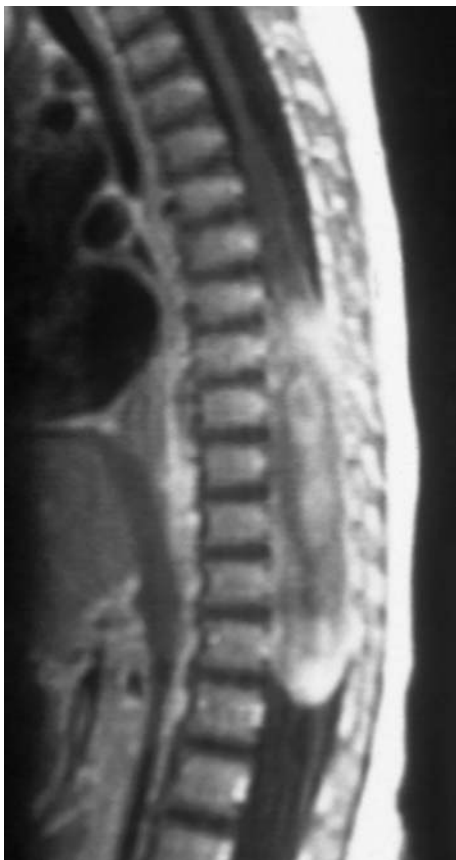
T1-weighted, contrast-enhanced, sagittal thoracic (a) and lumbar (b) MRI scans of an intramedullary WHO grade I astrocytoma with patchy contrast enhancement at Th10–L5 in a 31-year-old woman. The tumor has grown exophytically down into the lumbar canal. c This anterior–posterior X-ray image demonstrates thinned pedicles from the lower thoracic spine down to L3. d The bone window computed tomography (CT) image of a lower thoracic vertebra, which shows the profound thinning of the pedicles even better
